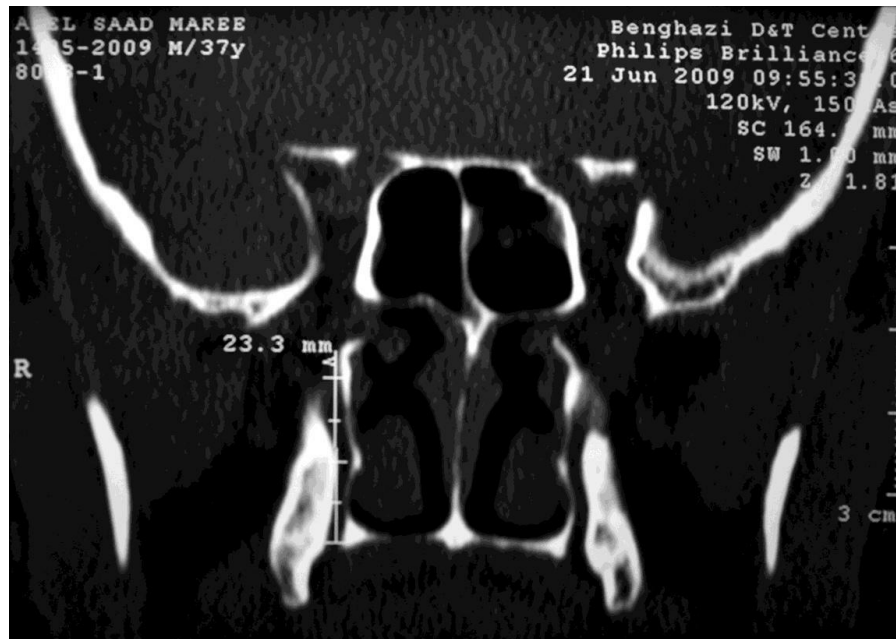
Photograph of a coronal CT image showing the direction and the measurement of the length of the greater palatine canal.
